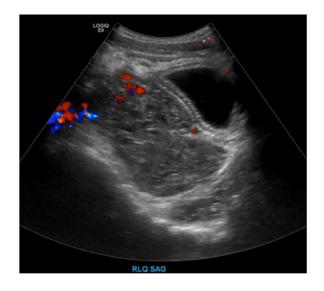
Right lower quadrant sagittal ultrasound demonstrating an absence of internal Doppler flow suggesting hematoma without active bleed.
